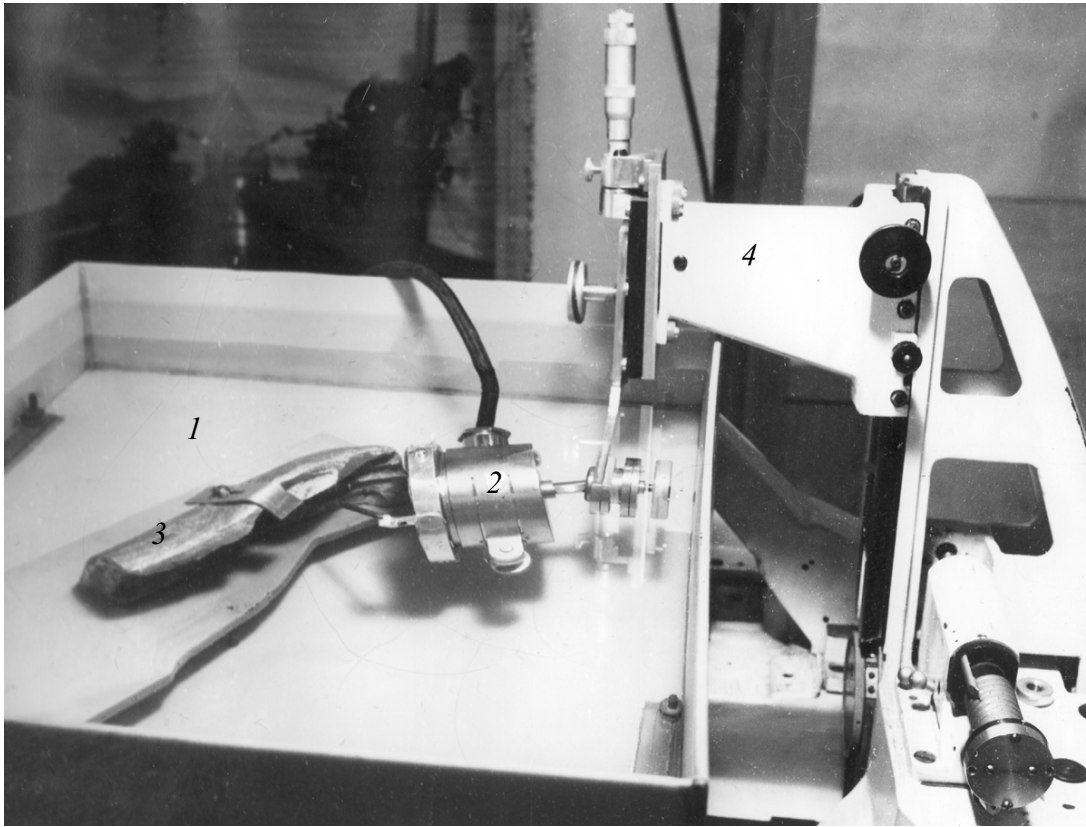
Apparatus for investigation of somatosensory sensitivity in human beings: 1 water bath, 2 focusing ultrasound radiator, 3 the casting to fix the arm of a subject, and 4 coordinate device.
